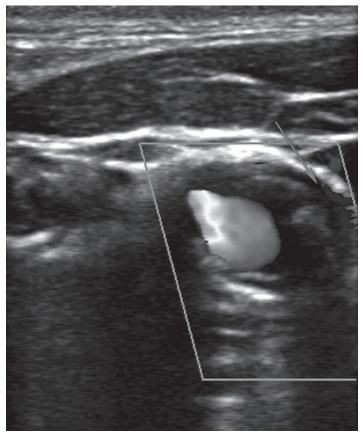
Color Doppler ultrasound (CDUS) showing aliasing, suggesting high velocity flow through narrowed true lumen. Flow is also noted through the false lumen (arrow).
